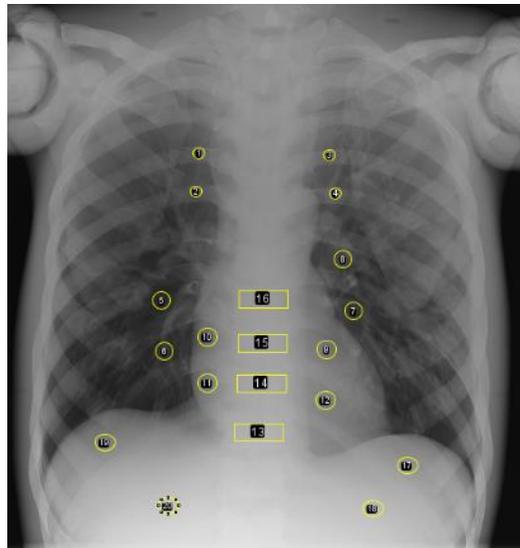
AP chest radiograph and anatomical ROI
